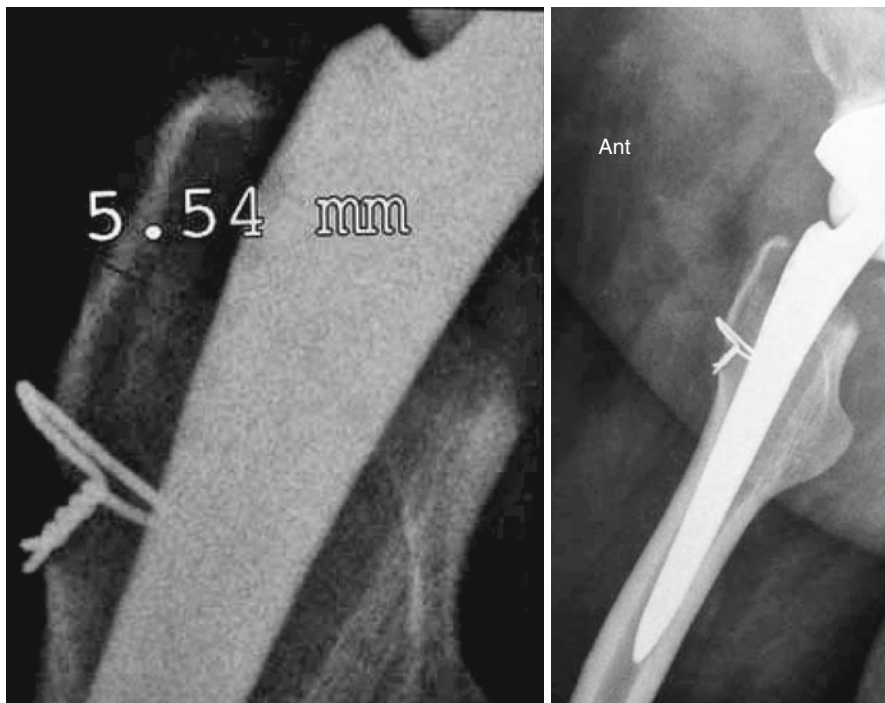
The lateral radiograph and focus show the reattachment of the trochanteric fragment with a wire
